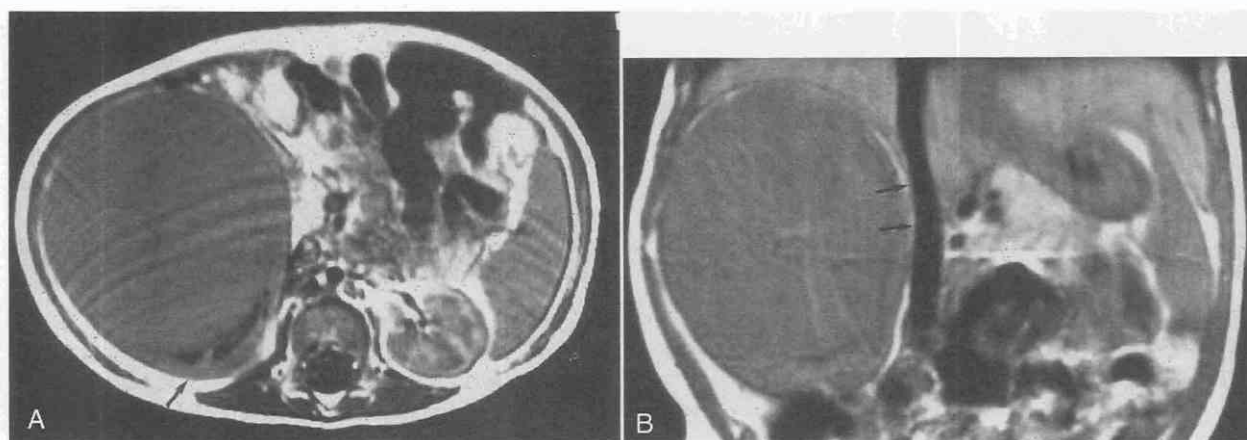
Wilms' tumor of right kidney shown by MRI (spin-echo, TR = 600 msec, TE = 15 msec). *A*, An axial image reveals that the mass is well defined and displaces normal renal tissue (arrow) posteriorly. *B*, A coronal image shows that the mass indents the inferior vena cava (arrows), but does not extend to the vena cava.
